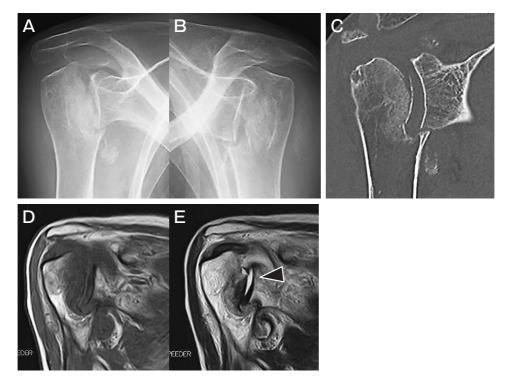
A, B: Radiographic findings of the patient's bilateral shoulder joints at the initial visit. The bilateral humeral heads were severely damaged. Plain CT (C) and plain MRI (D, E) of the right shoulder joint. The CT images show an insufficiency subcapital humeral fracture, but the glenoid side was intact. A damaged humeral head is shown in the T1 low-intensity area (D), and the T2 high-intensity area (*black arrowhead*) demonstrated joint effusion in the glenoid joint (E).
